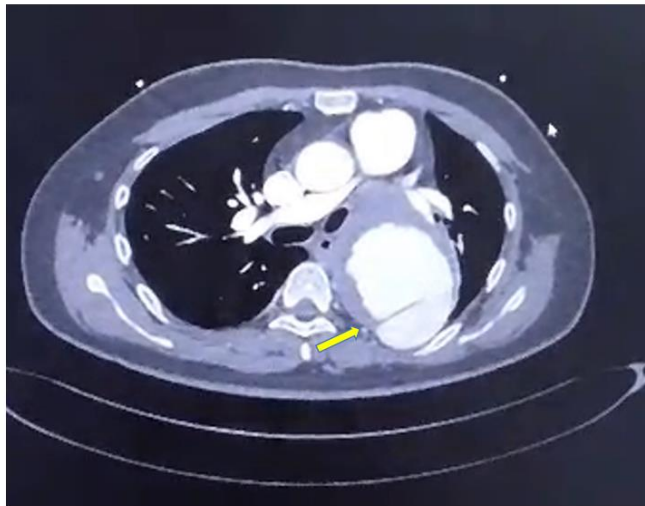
axial view of CTA showing; Yellow arrow: entry point of aortic dissection in descending thoracic aorta
